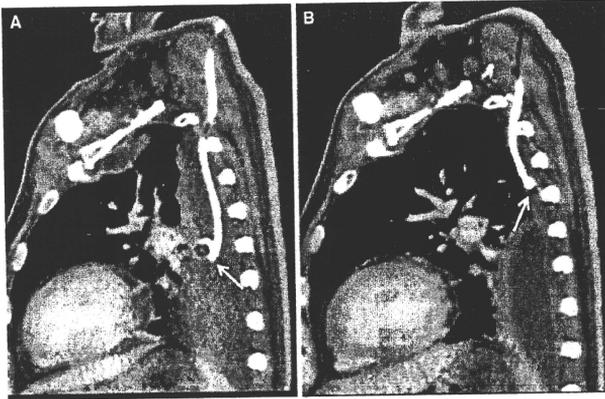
Sagittal reconstructed CT after the procedure. A The sagittal CT image taken on the next day after the procedure. B The CT taken after 2 weeks
